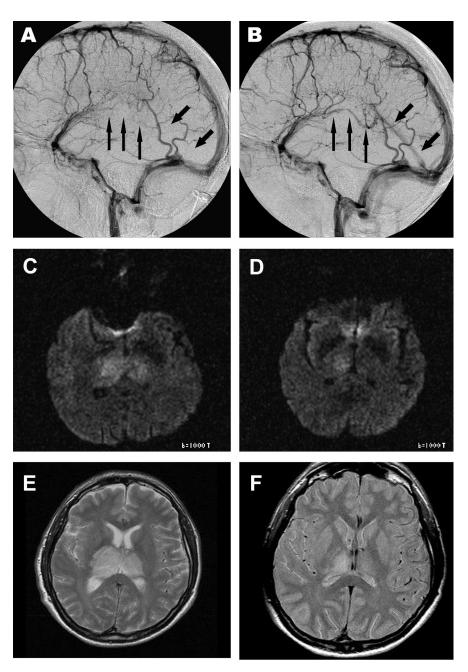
(A) Right internal carotid angiogram (late venous phase, lateral view) before treatment. None of the inner cerebral veins or the straight or inferior sagittal sinus is visualized (arrows on straight sinus and right internal cerebral vein). (B) Right internal carotid angiogram (late venous phase, lateral view) performed after intraarterial thrombolysis. The internal cerebral veins, vein of Galen, and the straight sinus are recanalized (the hypoplastic inferior sagittal sinus was only filled by the left internal carotid and the basal veins of Rosenthal through the vertebrobasilar system, not shown). (C) Axial diffusion-weighted MRI after admission of the patient to the hospital showed extensive bilateral thalamic edema. (D) Diffusion-weighted MRI 5 days after treatment with recombinant tissue plasminogen activator showed resolution on the left and a marked decrease of the lesion in the right thalamus. (E) T2-weighted MRIs showed increased signal and marked swelling of the right more than of the left thalamus, including the right inner capsule. (F) T2-weighted MRI after treatment revealed a complete release of the spaceoccupying effect, normalization of the signal on the left, and remnant increased signal on the right with flow void of the inner veins.
